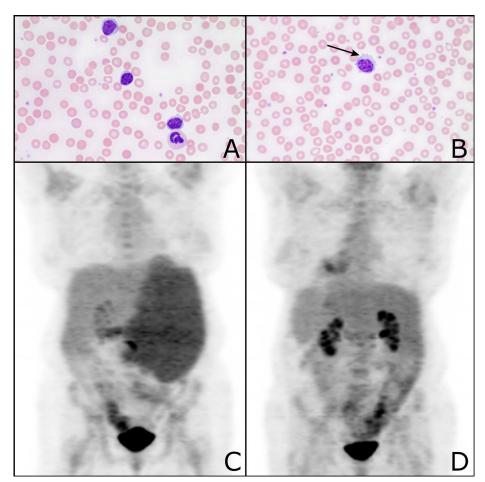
Peripheral blood smear showing lymphocytosis with (A) small mature lymphocytes and (B) occasional lymphocytes with cytoplasmic projections (arrow). (C) Whole body ¹⁸fluorodeoxyglucose positron emission tomography/computerized tomography (¹⁸FDG-PET-CT) scout film showing splenomegaly and diffuse increased uptake in the spleen. (D) Follow-up ¹⁸FDG-PET-CT showing complete metabolic response.
